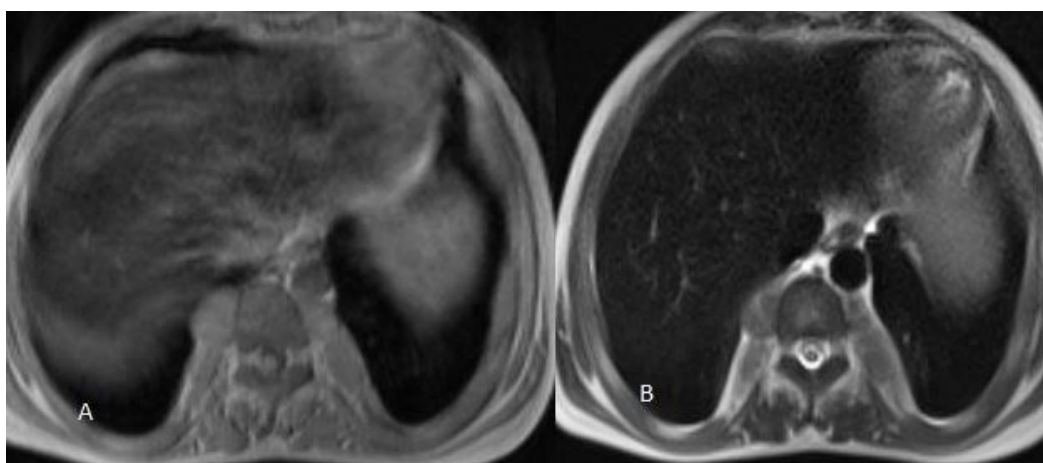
A- MRI Abdomen (Axial T1), B-(Axial T2)- showing bilateral paraspinal lesion in lower dorsal spine appearing hypointense in both T1 and T2WI.
